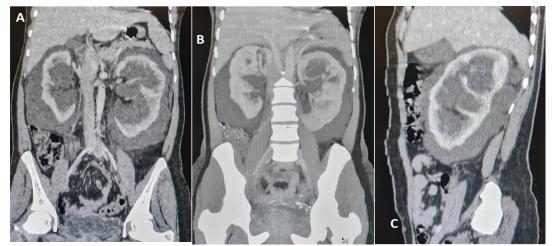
(A, B and C): Abdominal CT in coronal reconstruction (A and B) and sagittal (C) showing bilateral perirenal fibrosis giving an appearance of hairy kidneys
